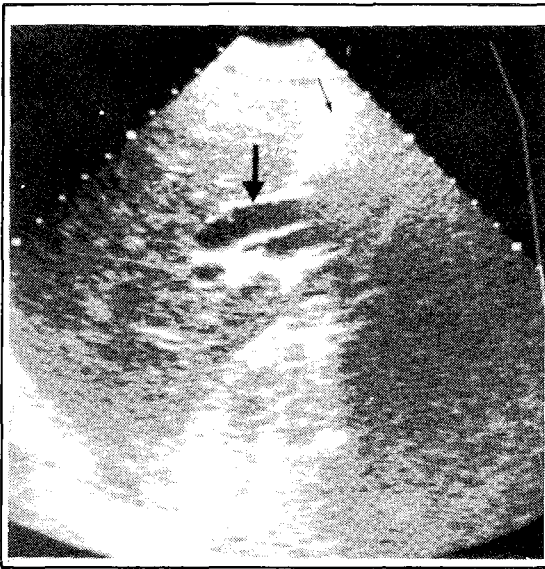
a) Oblique ultrasound showing a mildly dilated proximal common duct. Bowel gas (small arrow) obscure the distal part of the duct.
